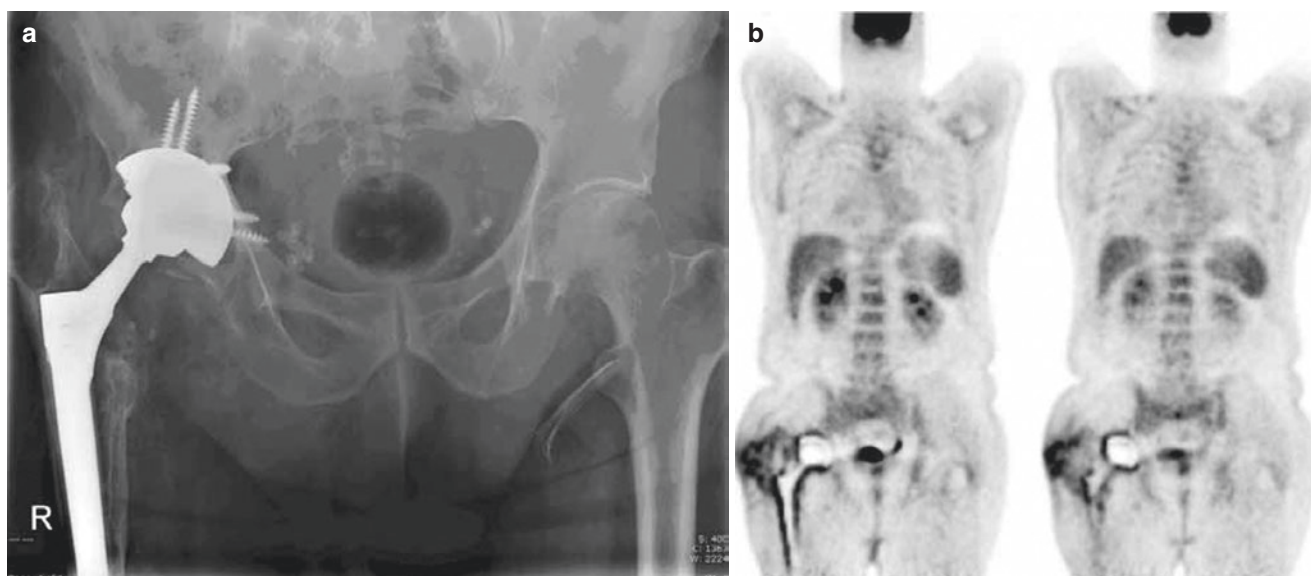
Patient with right hip arthroplasty, presenting with pain and fistula around the right hip. (a) X-rays show radiolucent lines around the shaft of the prosthesis consistent with hip loosening. (b) [^{18}F]FDG PET (coronal sections at two different levels) shows irregularly increased tracer uptake around both components (acetabulum and femur) of the total hip arthroplasty, in continuity with the fistula in lateral side of the hip. Enhanced tracer uptake can also be seen in the right
